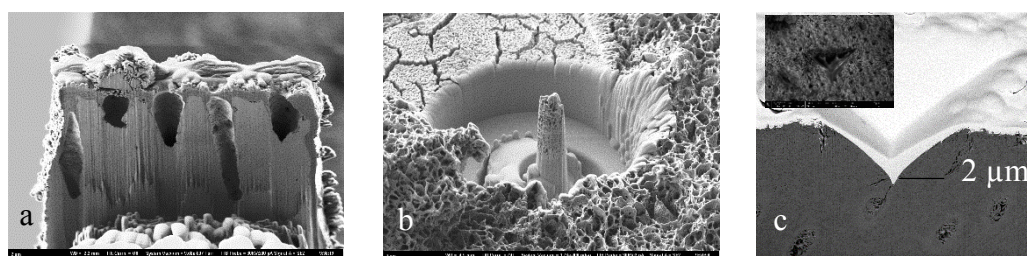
(a). FIB slice through cube after X-ray tomography, (b) FIB prepared micropillar, and (c) slice from a slice and view set looking at crack propagation (insert shows SE image of indent).
